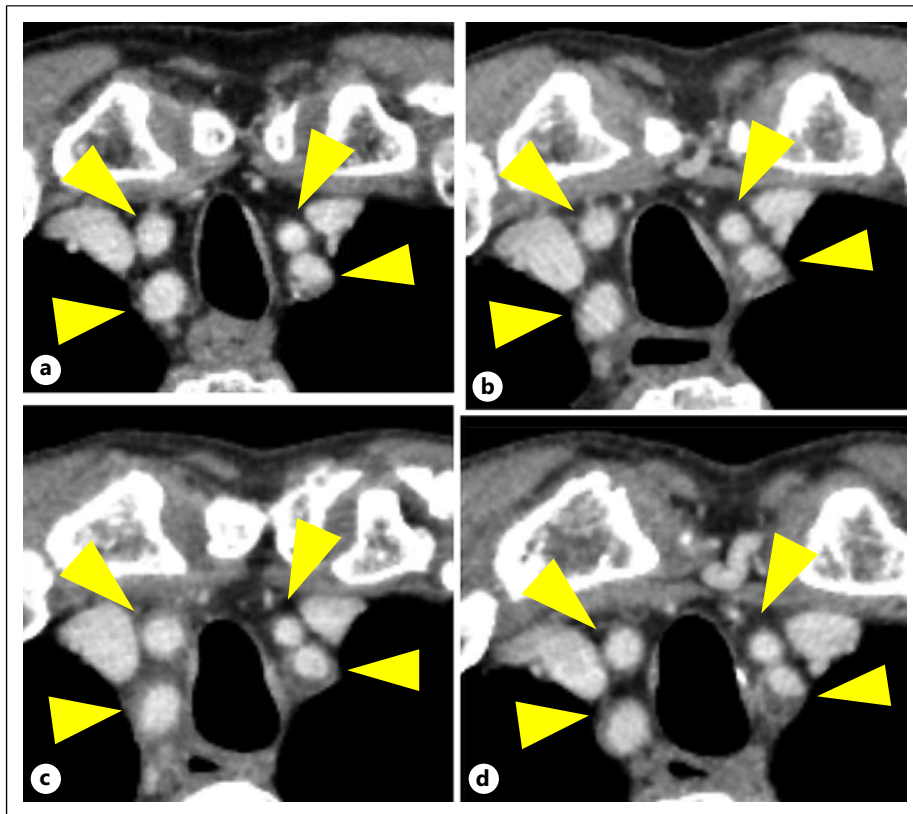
CT scan findings: the bilateral common carotid artery and the bilateral subclavian arteries (yellow arrows). a Before administration of G-CSF agents, (b) on day 18 after the first pegfilgrastim administration, (c) on day 11 after the second pegfilgrastim administration, (d) on day 9 after the start of filgrastim administration.
